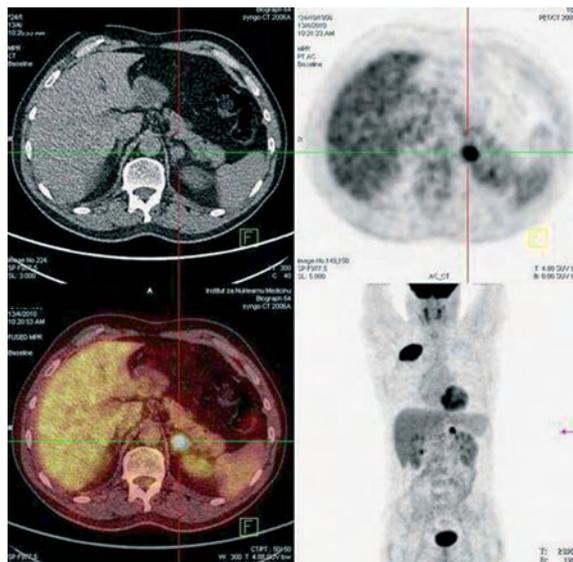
Increased F-18-FDG uptake (SUVmax 12.3) in the left suprarenal gland- unexpected distant metastases of non small cell lung cancer (NSCLC)
